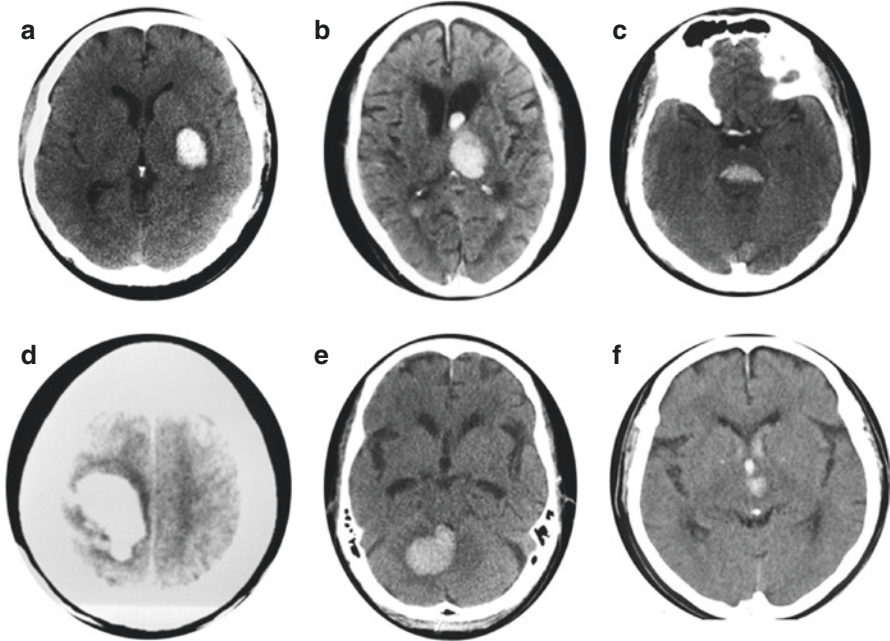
Noncontrast head CT scan is the usual initial imaging procedure of choice. It is rapid, has few contraindications, and easily demonstrates blood as high density within the brain parenchyma immediately after hemorrhage. (a) Putaminal; (b) thalamic; (c) pontine; (d) lobar; (e) cerebellar; (f) midbrain. (Author's departmental archive)
